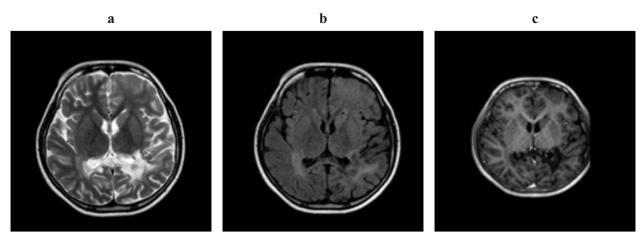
a) and b) Axial T2W and FLAIR MR images demonstrate confluent hyper intense signal areas in splenium of corpus callosum and bilateral parieto-occipital deep periventricula white matter with sparing of subcortical U fibers.
